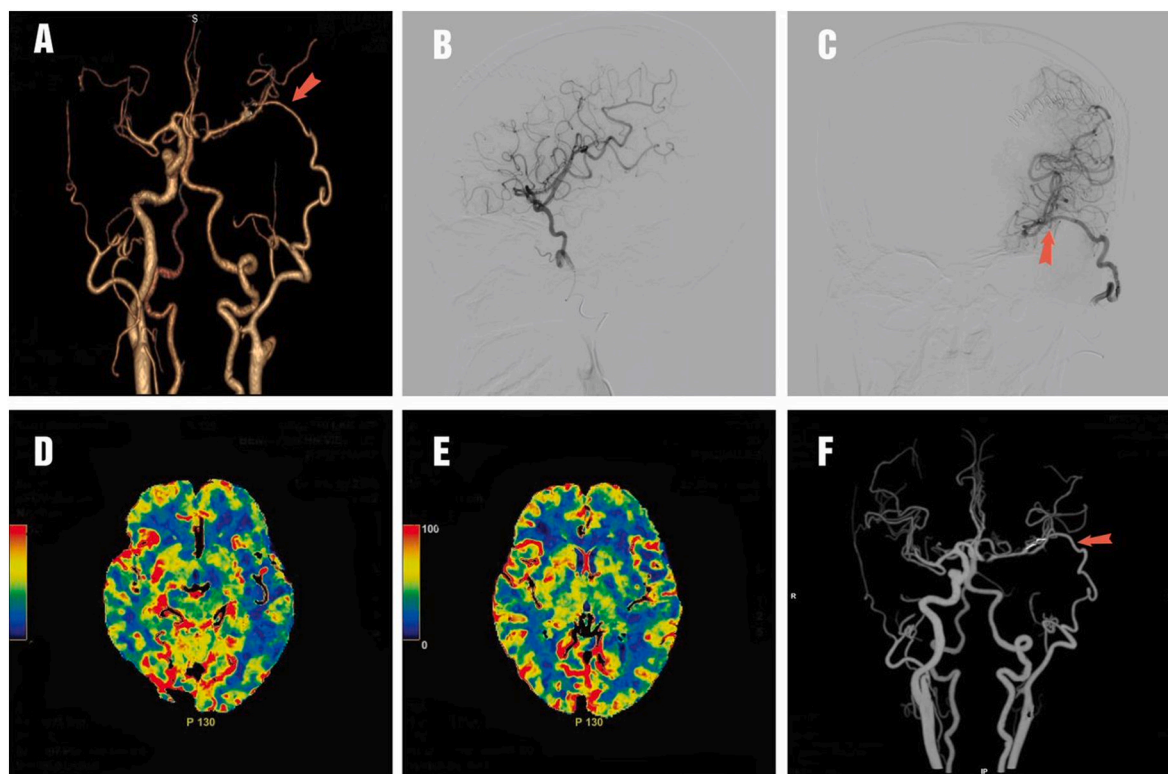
The CTA (A) and selected DSA (B, C) series after emergency bypass surgery showed good graft patency (red arrow). D, E, F: The CTA and CT perfusion after one month showed good graft patency (F; red arrow), and the color-coded map showed no reduction in the flow on the left as compared to the right side (D and E).
